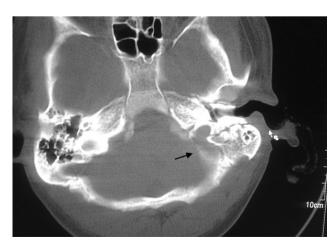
Axial CT-scan showing fracture involving left jugular foramen (arrow).
